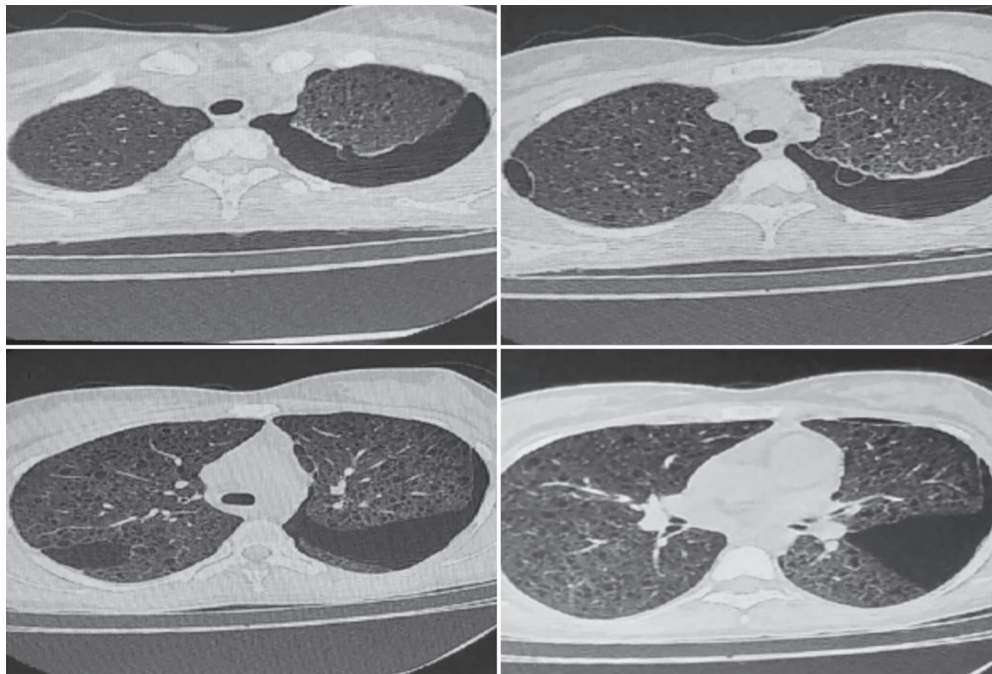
Computed tomography (CT) chest showing bilateral cystic lesions and left-sided pneumothorax
